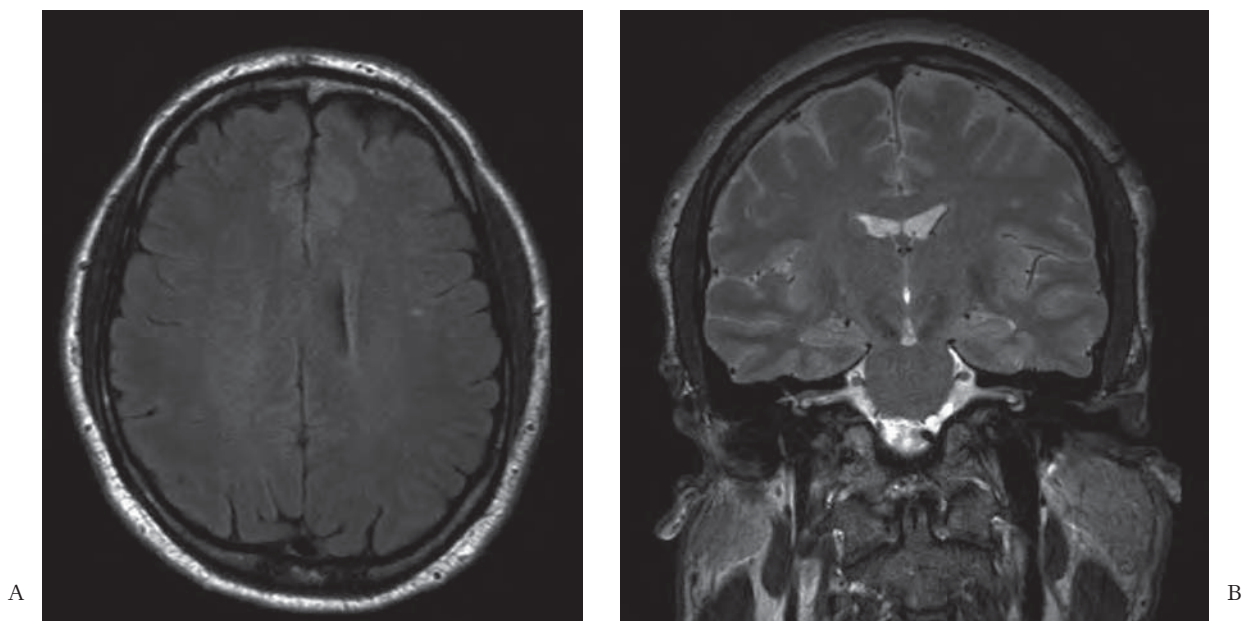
MRI images of patient 2
